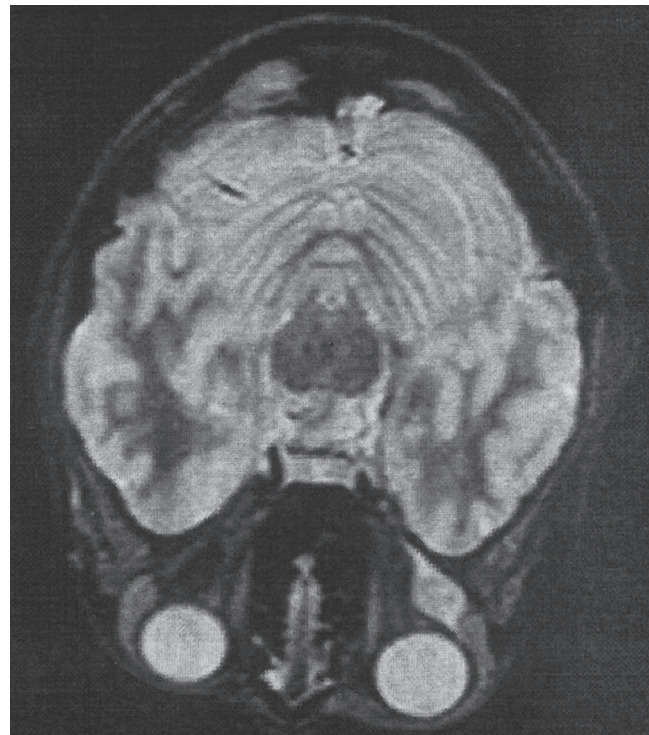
Axial T2W MR image showing a hyperintense lesion in the lateral rectus muscle of the right orbit.
